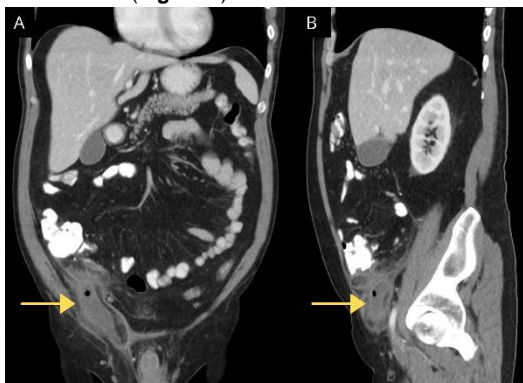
Abdominal computed tomography showing right inguinal hernia with an incarcerated, inflamed vermiform appendix (yellow arrow).
